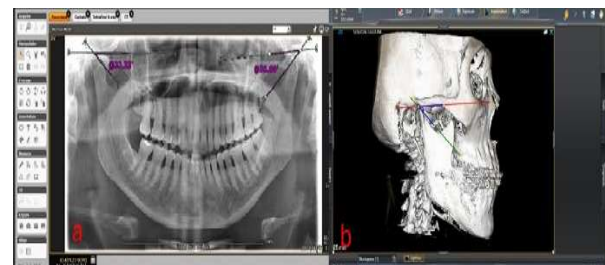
HCPA measurements on (a) Digital panoramic radiography and (b) CBCT.
